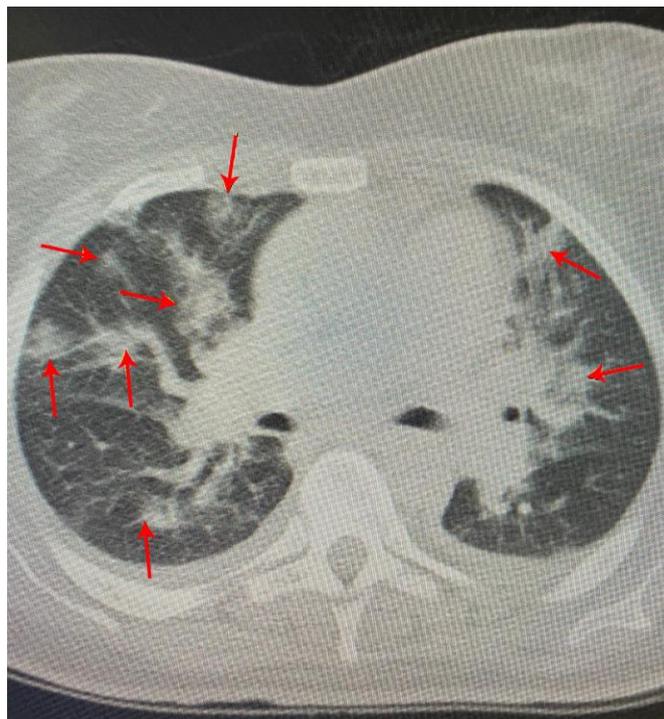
Low dose lung CT scan without contrast: multiple patches of ground-glass opacities and consolidations are noted diffusely in both lung parenchyma, which is predominantly distributed in peripheral regions with involvement of 70% of parenchyma.
